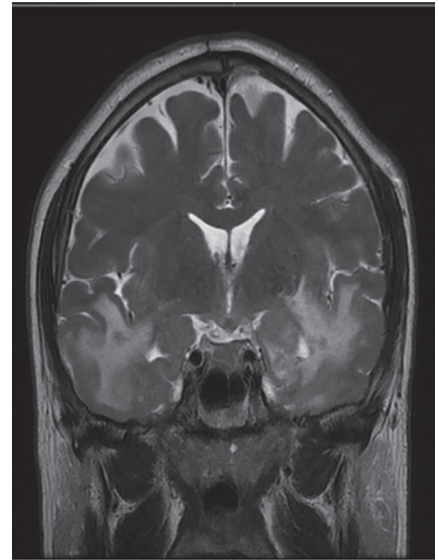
Corrona / T2 MRI sequence showing extensive vasogenic oedema.
